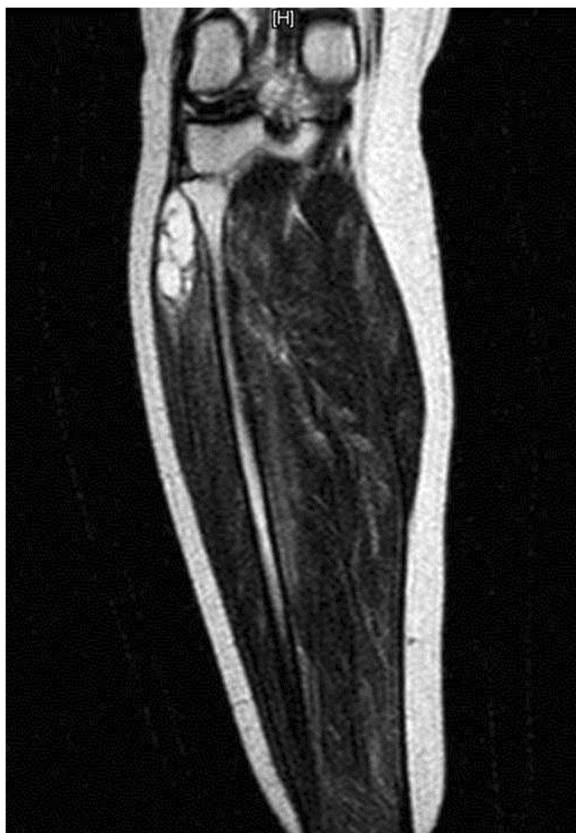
Characteristic magnetic resonance imaging findings of ganglion cyst with high signal intensity on the T2 sequence images.
